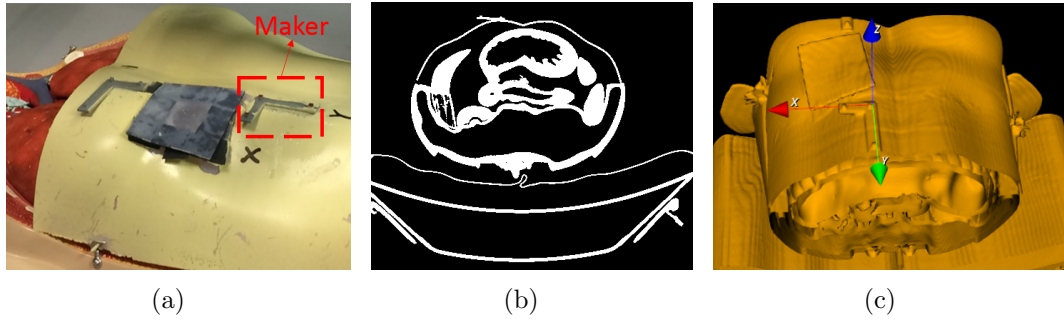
Preoperative CT planning data in the patient coordinate system. (a) marker on the patient. (b) 2D CT image. (c) 3D reconstructed patient model.
